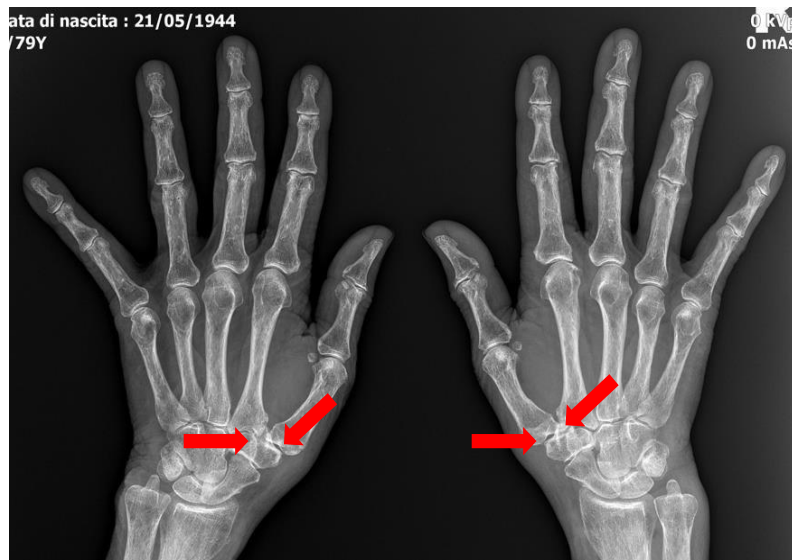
Antero-posterior radiograph projection of both hands documenting grade 2 bilateral rhizarthrosis with slight reduction of joint space (arrows).
